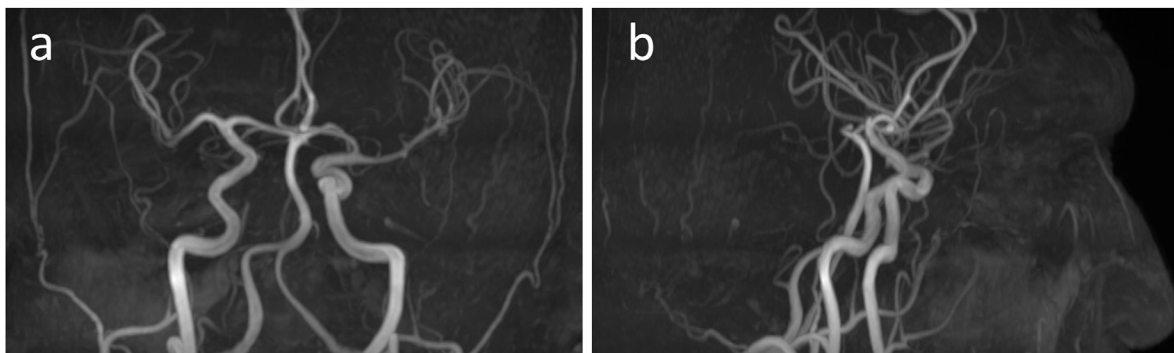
MRI angiography imaging of the patient a) anterior posterior b) lateral.
